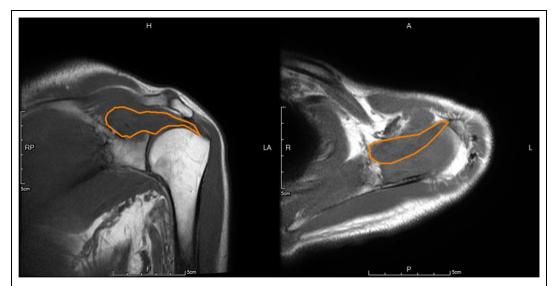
Pre-operative MRI shows mass lesion about the supraspinatus and infraspinatus region.
